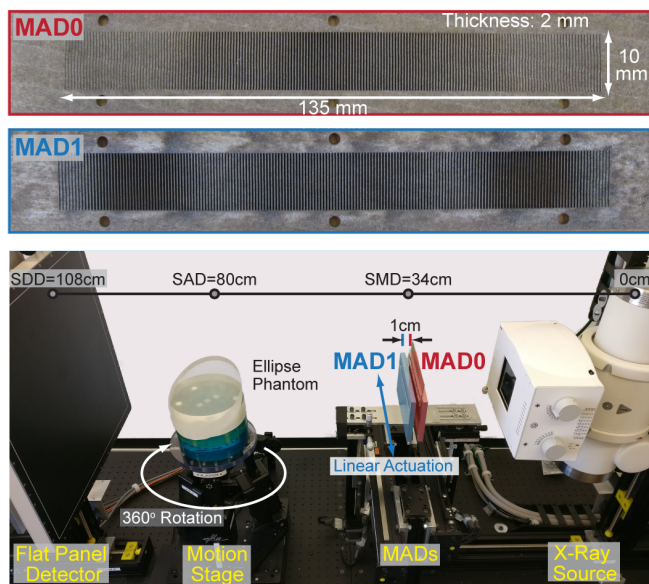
Photos of the two MADs and setup of the dual-MAD system on an experimental CBCT bench.
